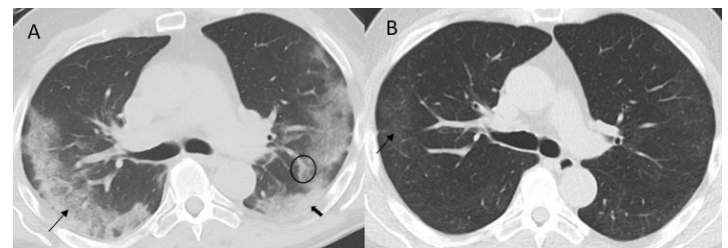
69-year-old man hospitalized for COVID-19 pneumonia. A) Baseline axial CT showing consolidations (thick arrow), vasodilatation (circle) and ground glass opacifications (thin arrow) with peripheral distribution. B) 3-month follow-up axial CT demonstrating discrete residual ground glass opacifications (thin arrow).
